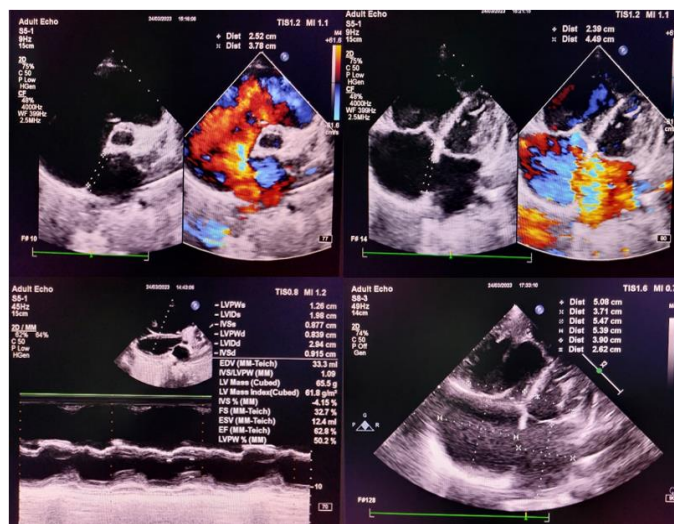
Echocardiography; ASD Secundum
